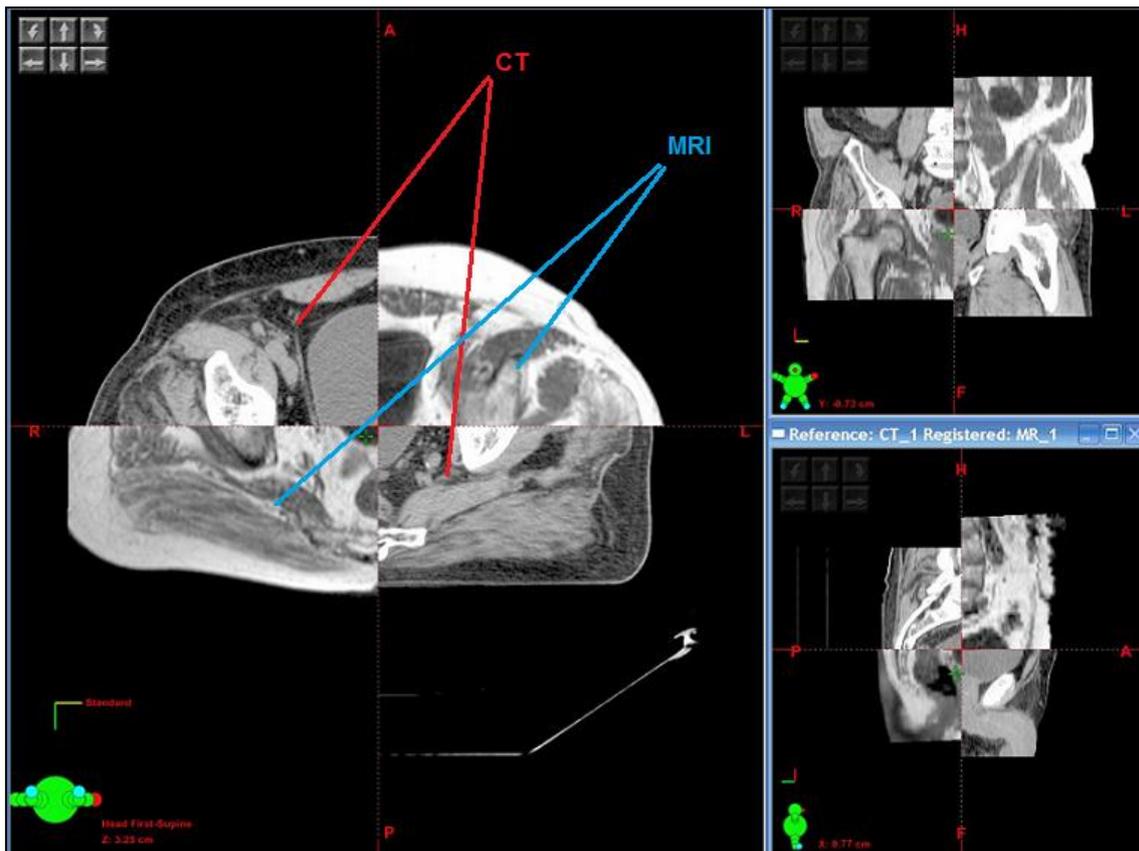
Pelvic CT/MR image registration.
